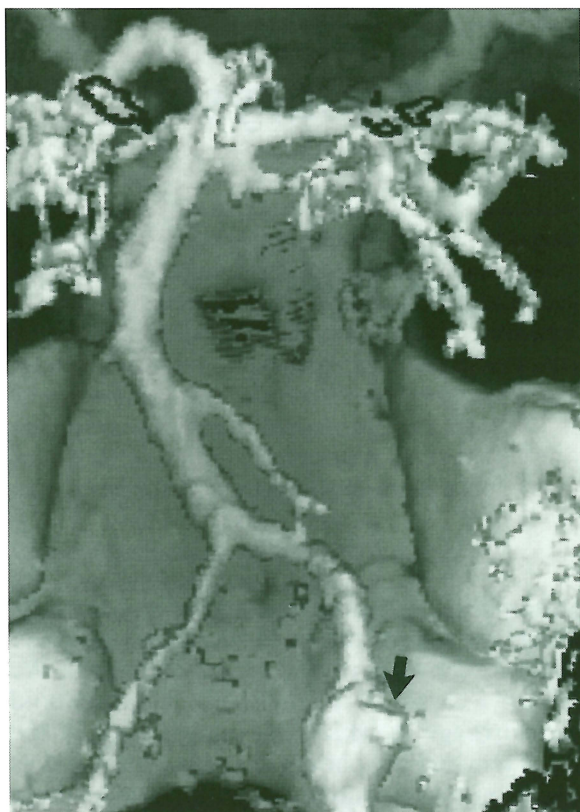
A 3D CTA image of the posterior fossa in an anatomic surface-rendered projection demonstrates a fusiform aneurysm of the distal intradural right vertebral artery. A prominent bleb or sac (arrow) projects from the dome.
